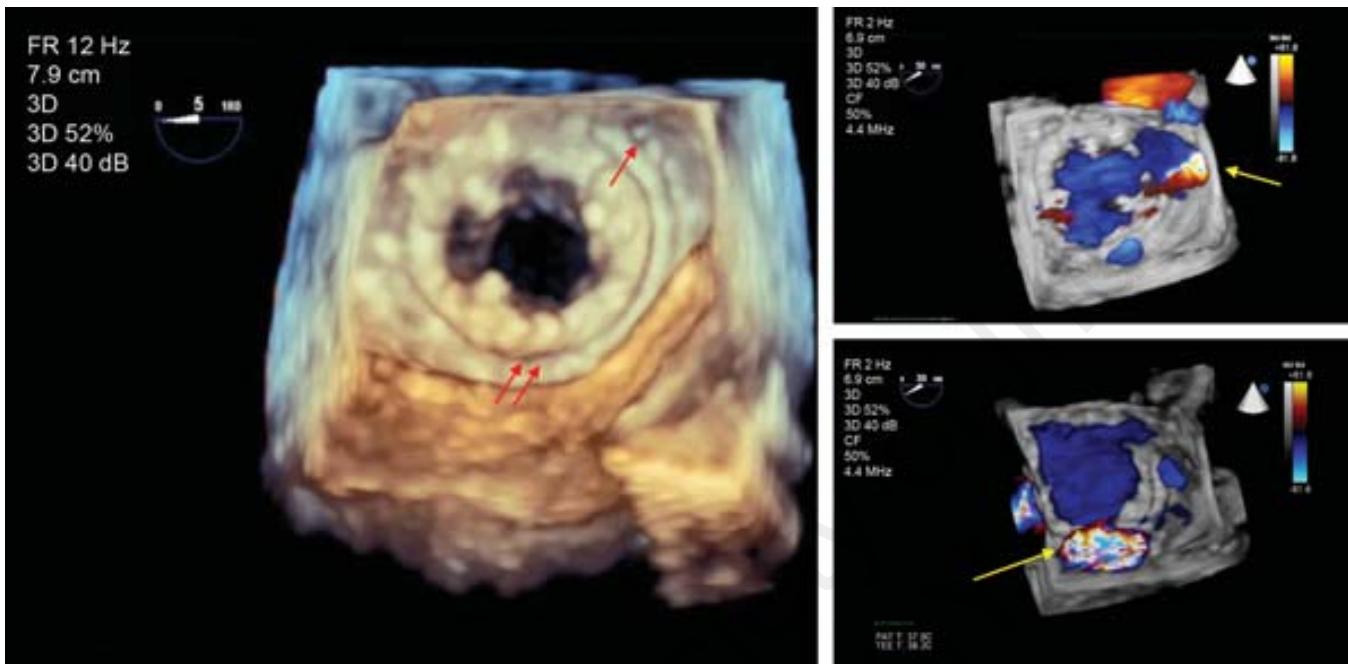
Paravalvular defects around a bioprosthetic mitral valve. Left—gray scale image showing the location of the defects (arrows); Right—color Doppler confirming the presence of mitral regurgitation through these defects.
